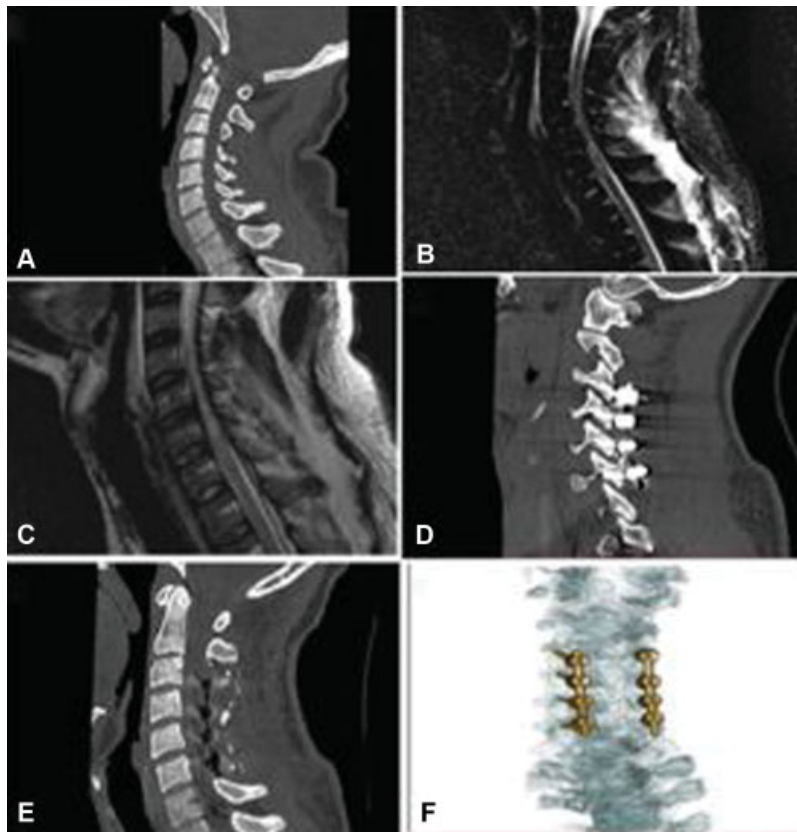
(A) CT at admission, without evident alterations. (B) MRI in a T2-weighted sequence with fat suppression with extensive hypersignal in posterior elements of the cervical spine and hypersignal in the cervical medulla, with evident compression, without listhesis. (C) MRI in a T2-weighted sequence, showing traumatic myelopathy from C4 to C7, bulging of diffuse disc from C5 to C6, determining vertebral canal stenosis and edema area in the cervical and dorsal muscle-adipose planes. (D and E) Postoperative sagittal section CT with laminectomy and cervical arthrodesis by posterior route between C3 and C6. (F) CT with 3D reconstruction showing the final aspect of the arthrodesis.
